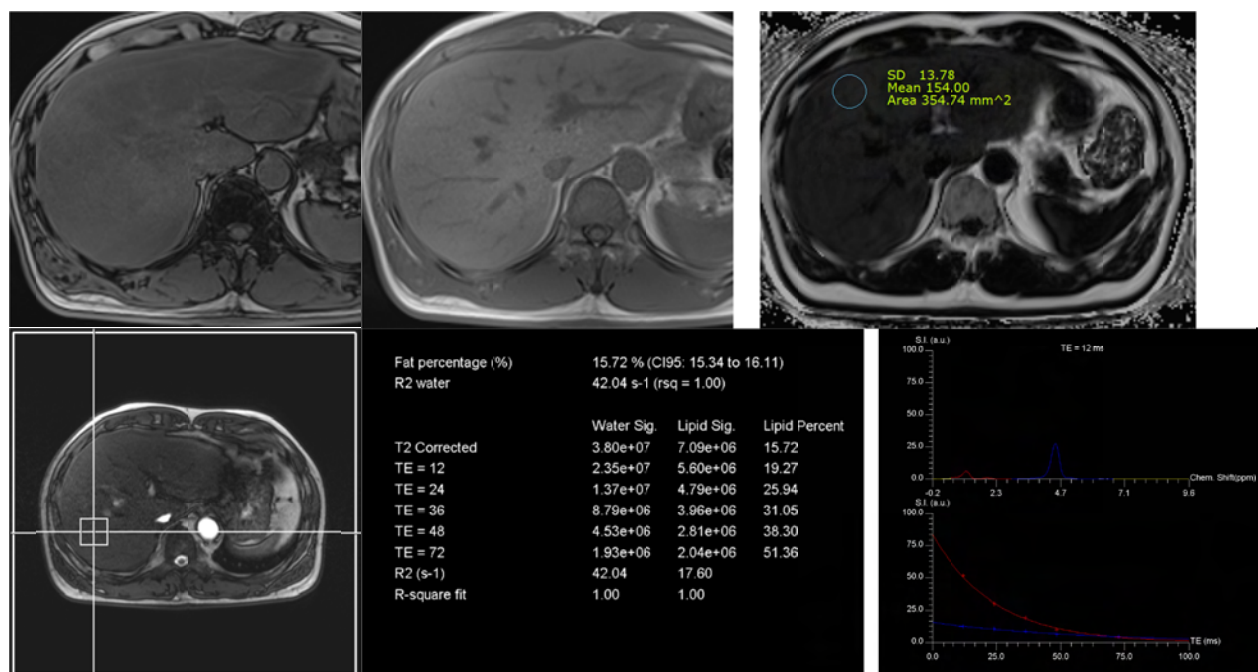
From left to right: DGE-MRI, T2\*-corrected CSI and T2-corrected multiecho BH <sup>1</sup>H-MRS
